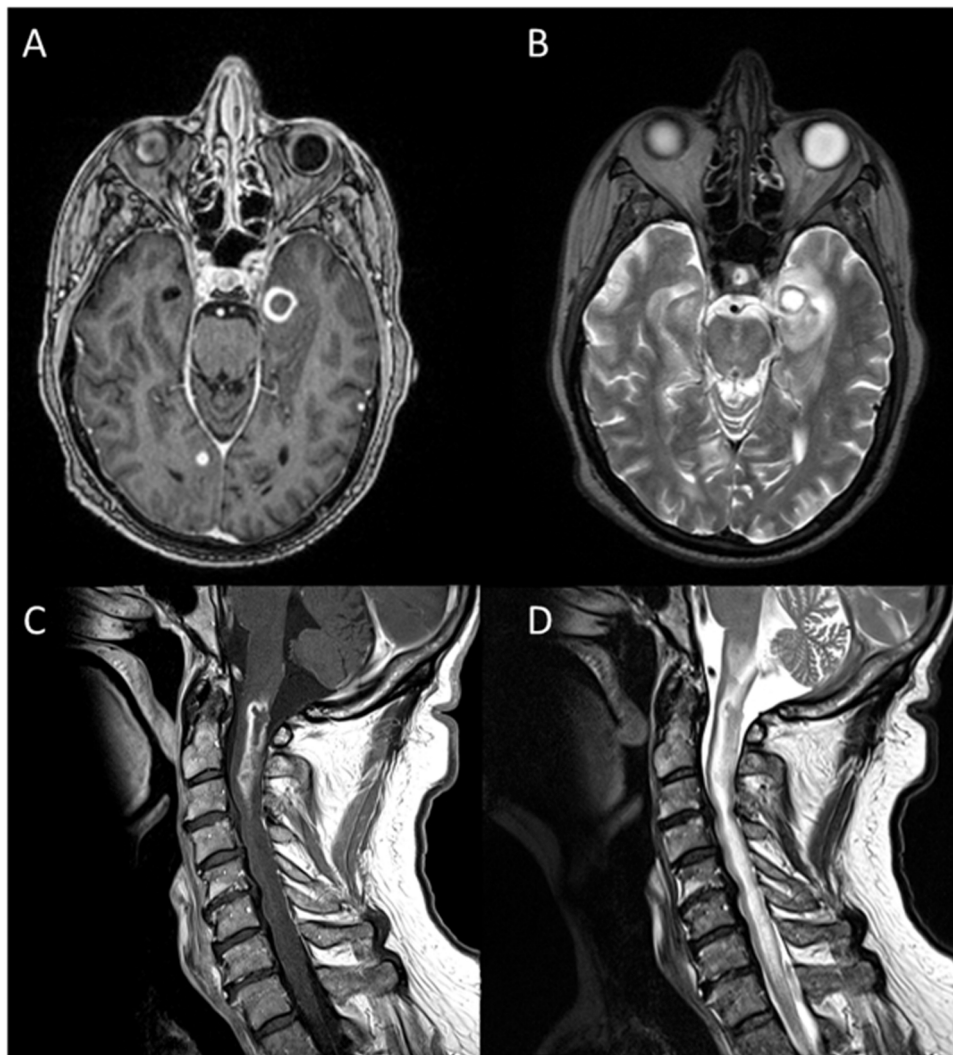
MRI brain T1 weighted imaging revealed lesion with ring-enhancement (A) with adjacent edema on T2 weighted imaging (B). MRI cervical spine T1 weighted showed diffuse hypoattenuation consistent with internal necrosis (C) and diffuse hyperattenuation of cervical spine cord on T2 weighted imaging (D).
